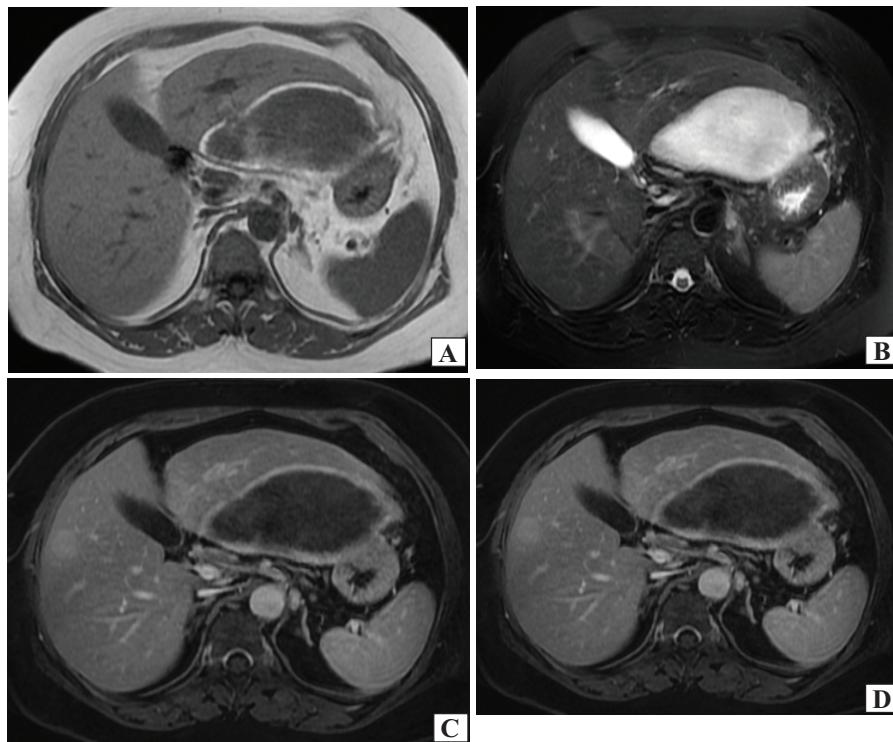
MRI of inflammatory hepatic adenoma.
